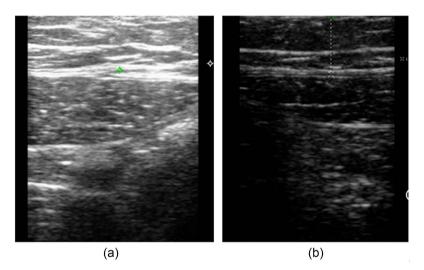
Ultrasonography—Left side: Pretreatment (a) and Post-treatment (b).
